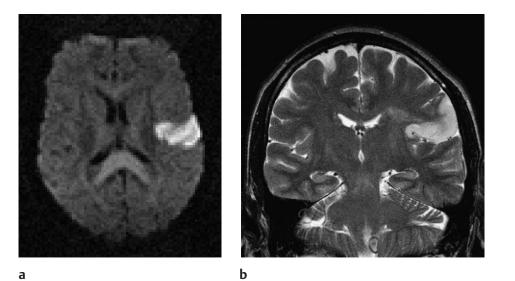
Cerebral infarct in Broca's area due to dissection of the left internal carotid artery (MRI).
